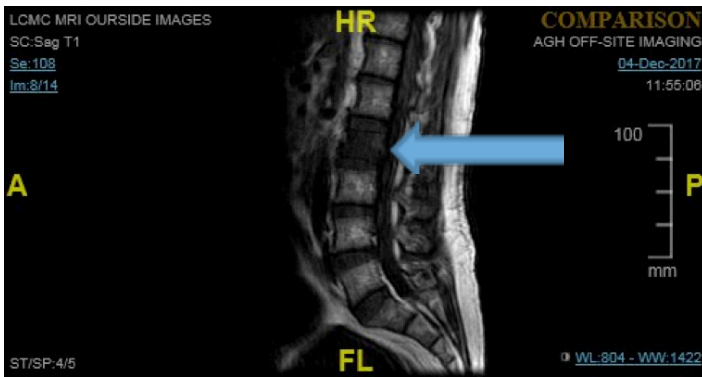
T1 weighed MRI of lumbar spine from outside hospital revealing abnormality at L2
